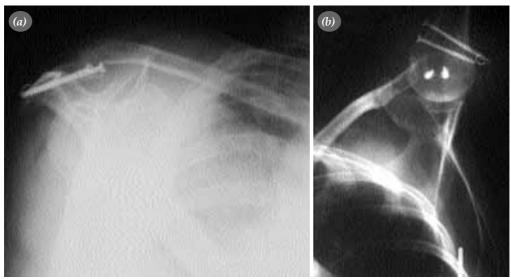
(a, b) The postoperative x-rays of a patient treated with cannulated screws and serklage wires.
